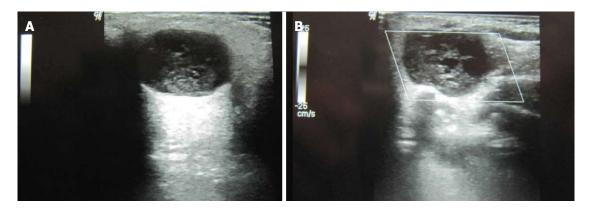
Ultrasound images. A: Left parotid gland shows presence of well defined hypoechoic mass lesion in the superficial lobe with posterior acoustic enhancement; On Color Doppler (B), no internal vascularity could be demonstrated.
